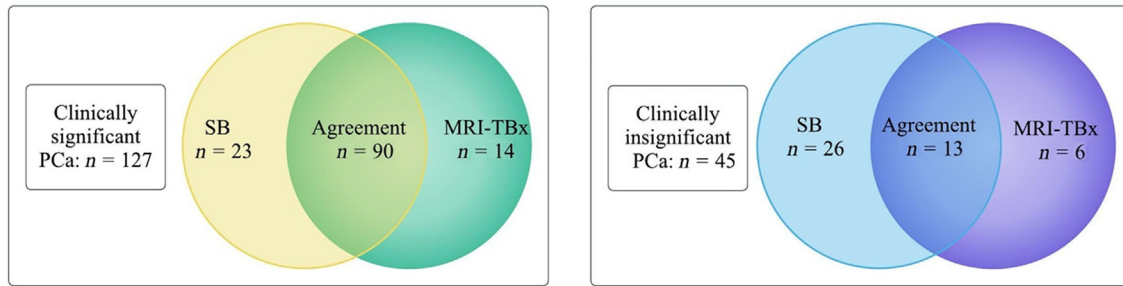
Agreement in the detection of PCa between SB and MRI-TBx and their added cases respectively in patients with suspicious mpMRI (PI-RADS >2). MRI-TBx = magnetic resonance imaging-ultrasound fusion biopsies; PCa = prostate cancer; SB = systematic biopsies.
